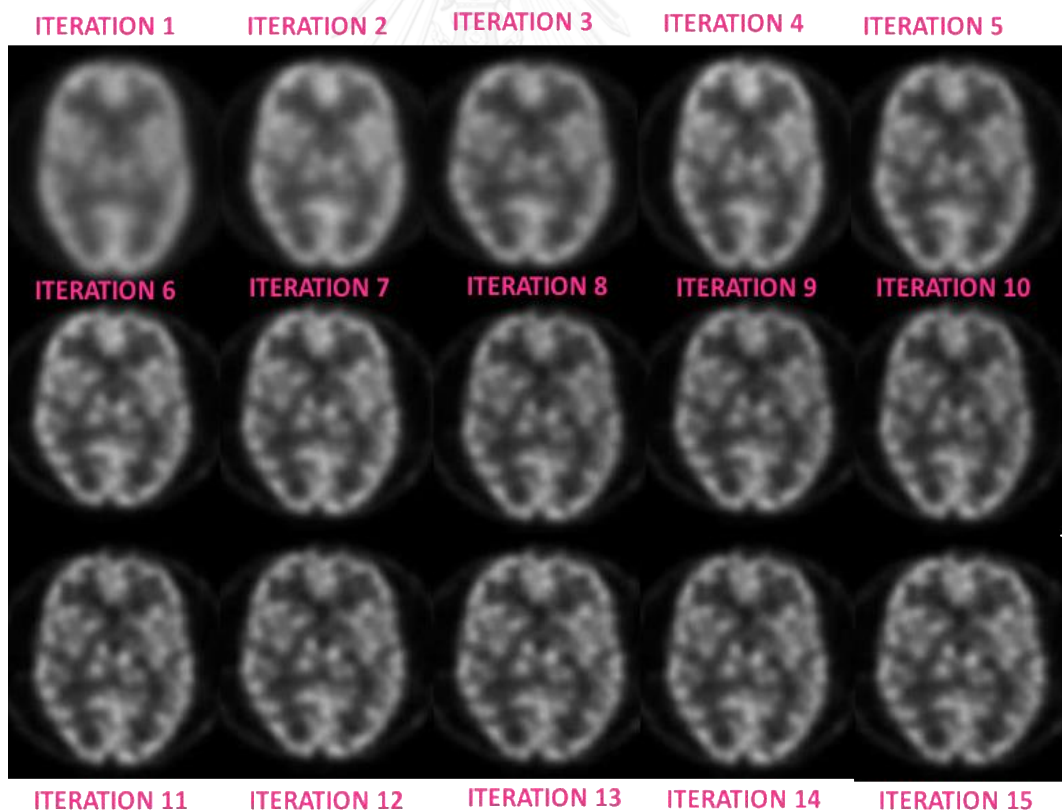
Figure B 3. The brain SPECT images by varying number of iterations in normal activity concentration (3D- OSEM)
